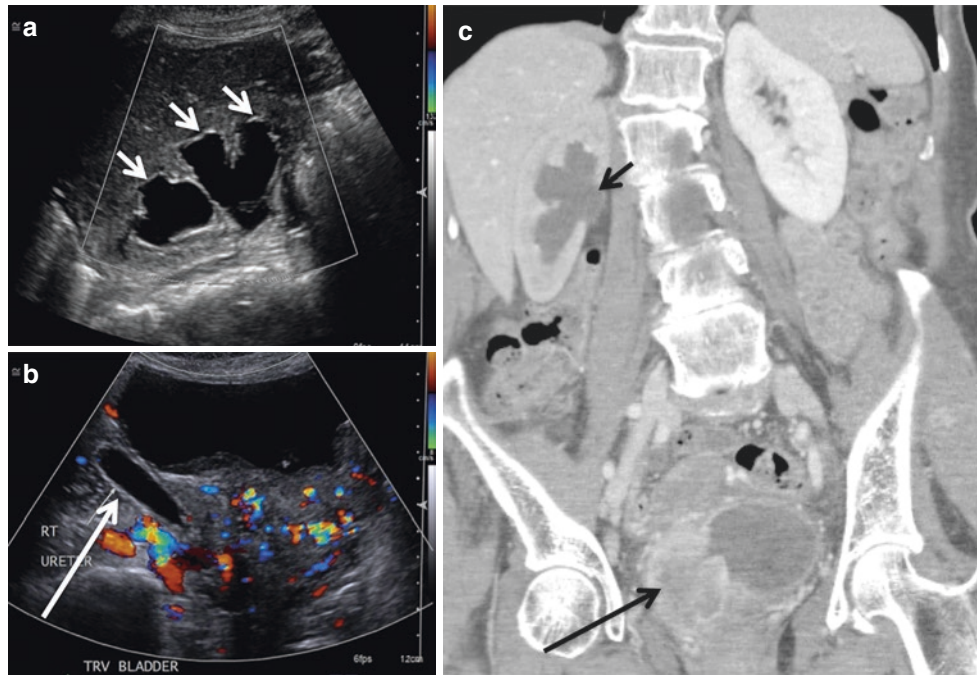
A 70-year-old female with urinary bladder urothelial carcinoma. (a) Initial sonographic image shows dilation of the renal collecting system with calyceal blunting (*short white arrows*). Subsequent sonographic image of the pelvis (b) shows dilation of the distal ureter (*long white arrow*), with vascularized soft tissue mass in the urinary bladder. Coronal CT image (c) redemonstrates hydronephrosis (*short*
